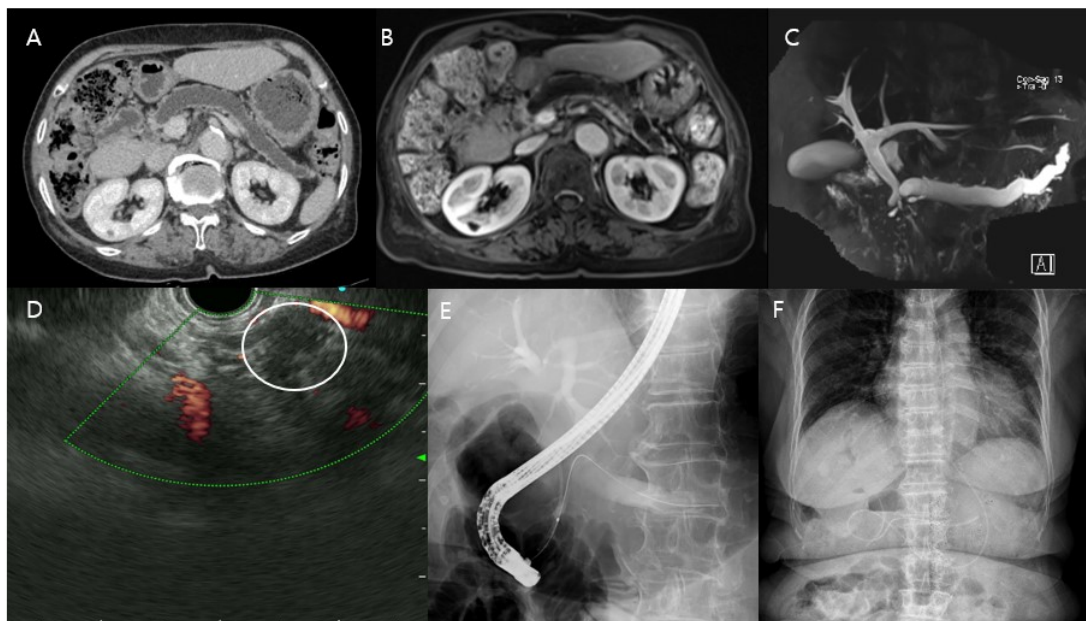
(A) Abdominal CT (A) showed diffuse dilation of pancreatic duct. (B, C) Arterial phase of pancreas magnetic resonance imaging and 3D Maximum intensity projection showed diffuse dilation of pancreatic duct. (D) EUS finding showed 18.5mm sized hypoechoic mass at the pancreatic neck (circle) with intervening vessel. (E) During endoscopic retrograde cholangiopancreatography (ERCP), pancreatogram showed diffuse p-duct dilation and obstruction at pancreas head. (F) Abdominal x-ray showing endoscopic nasopancreatic drainage (ENPD) catheter.
